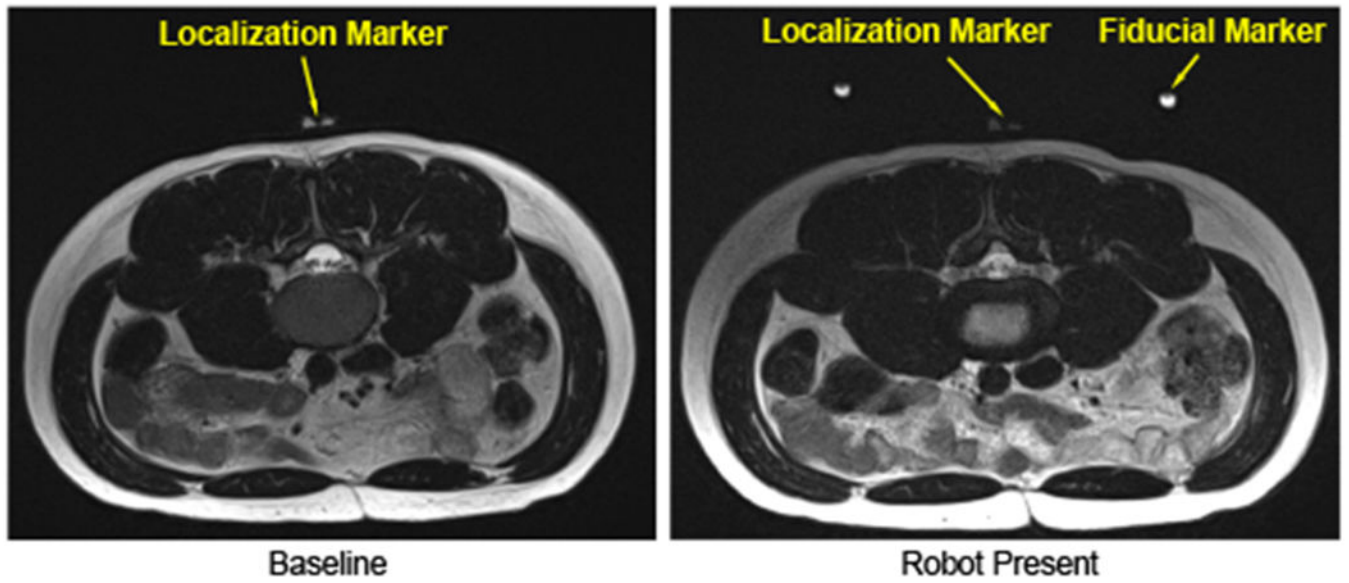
Qualitative imaging quality comparison. T2-weighted blade respiratory gating images were taken in the lumbar spine region with two configurations: no robot inside the scanner (left), and robot attached to the back (right).
